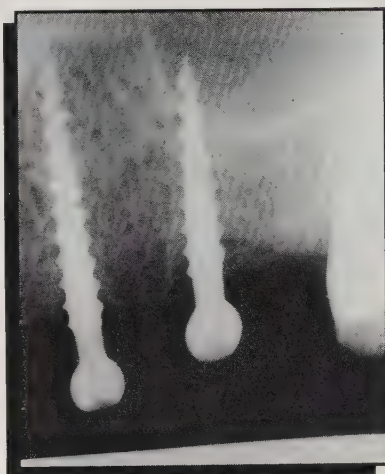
Radiographic representation of the Le Comresse osseointegrated implant which was used in this patient.
